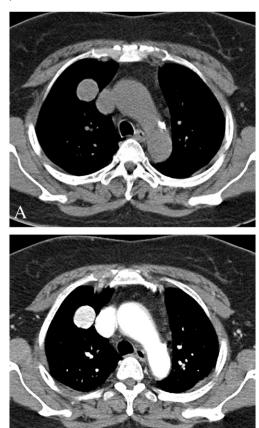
Chest CT images of (A) unenhanced and (B) enhanced scan. A 2.5-cm diameter well-circumscribed nodule in the anterior segment of the right upper lobe shows strong and homogeneous enhancement.
